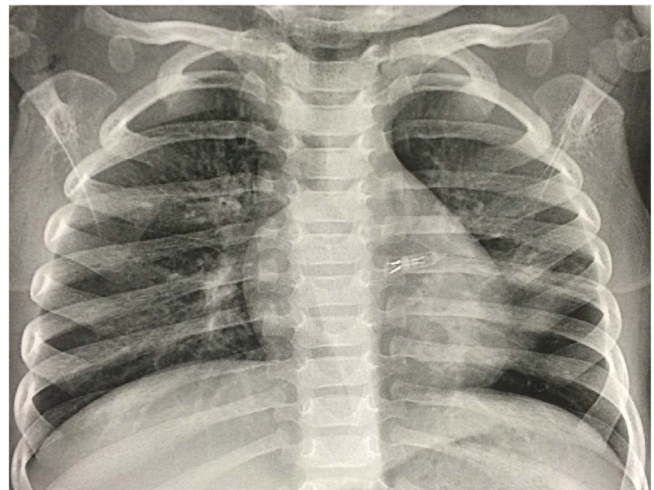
Chest X-ray of a 14-month-old girl showing a U-shaped radiopaque foreign body into the left main bronchus.
